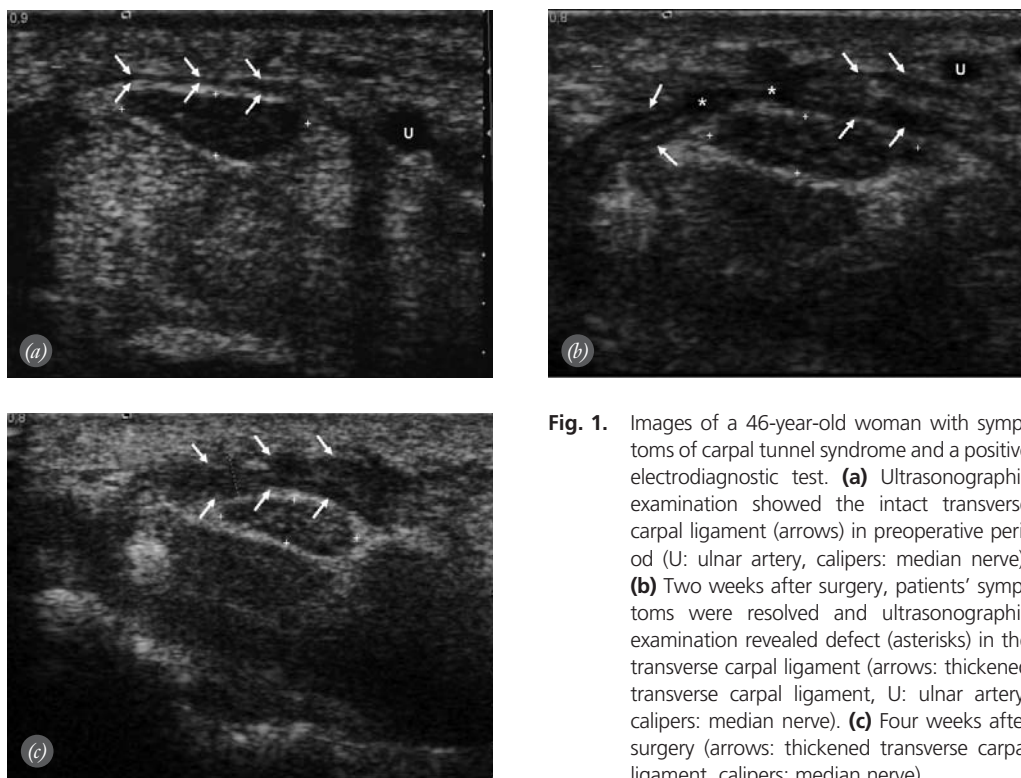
Images of a 46-year-old woman with symptoms of carpal tunnel syndrome and a positive electrodiagnostic test. (a) Ultrasonographic examination showed the intact transverse carpal ligament (arrows) in preoperative period (U: ulnar artery, calipers: median nerve). (b) Two weeks after surgery, patients' symptoms were resolved and ultrasonographic examination revealed defect (asterisks) in the transverse carpal ligament (arrows: thickened transverse carpal ligament, U: ulnar artery, calipers: median nerve). (c) Four weeks after surgery (arrows: thickened transverse carpal ligament, calipers: median nerve).
